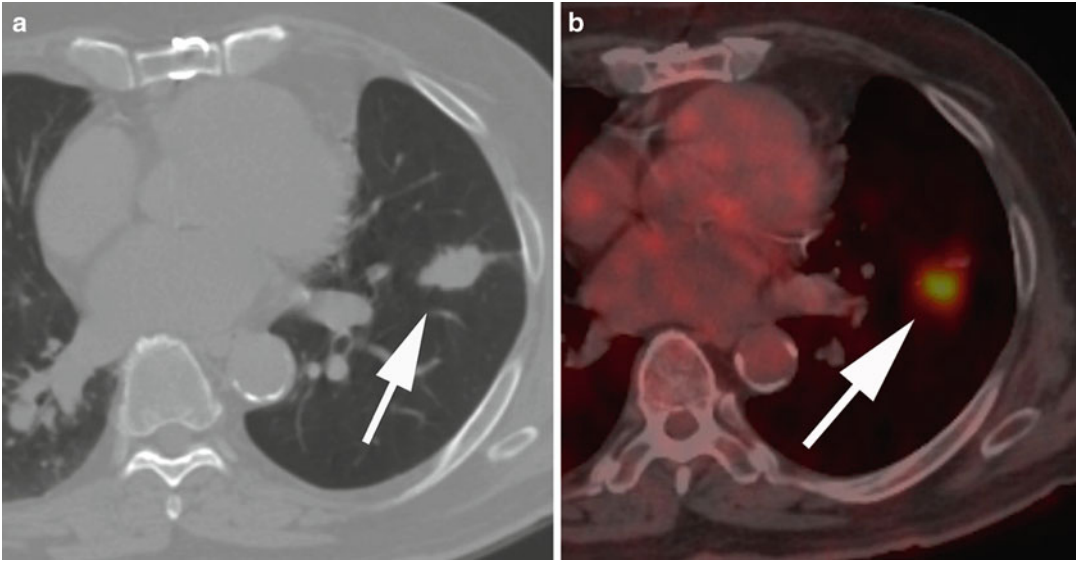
True positive PET/CT. (a) Axial CT image reveals oblong lobulated left lower lobe nodule (*arrow*). (b) Fused PET/CT image shows elevated uptake within
